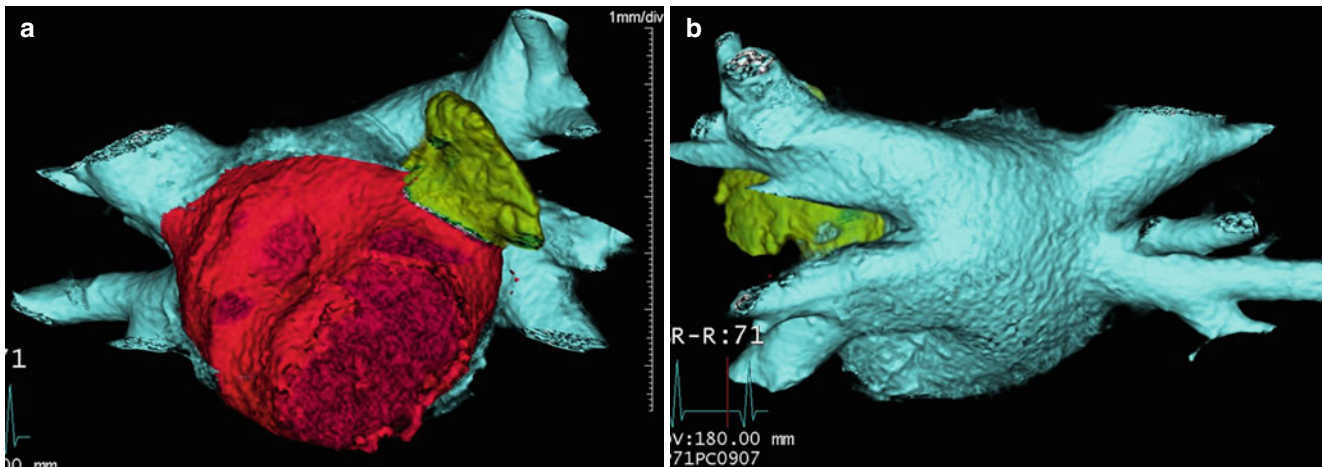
Three anatomic compartment of the left atrium. Volume-rendered CT image on anterior (a) and posterior (b) aspects of the left atrium (LA) shows three anatomic compartment of the LA: the venous LA (blue), the left atrial appendage (red), and the anterior LA (green)
